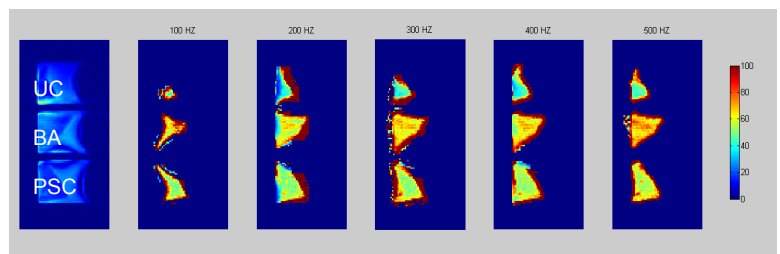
T1 ρ map of cirrhotic human liver explants at different spin-lock frequencies. Within the same stage of fibrosis (F4 on the Metavir scale), T1 ρ MR imaging is able to distinguish smaller, more subtle changes with fibrosis. According to the collaborating pathologist, here, UC had the least fibrosis and BA had the most, with PSC being in the middle.
